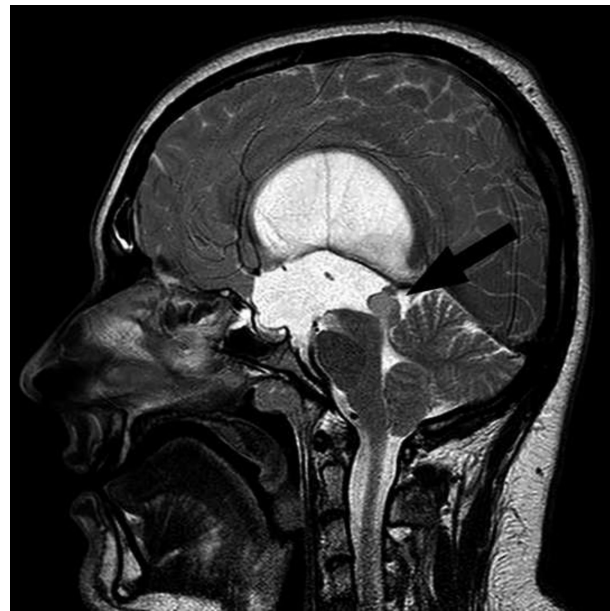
Sagittal T2 MRI scan of patient #2; the arrows' tip shows the tumor originating in between the superior and the inferior colliculi.
